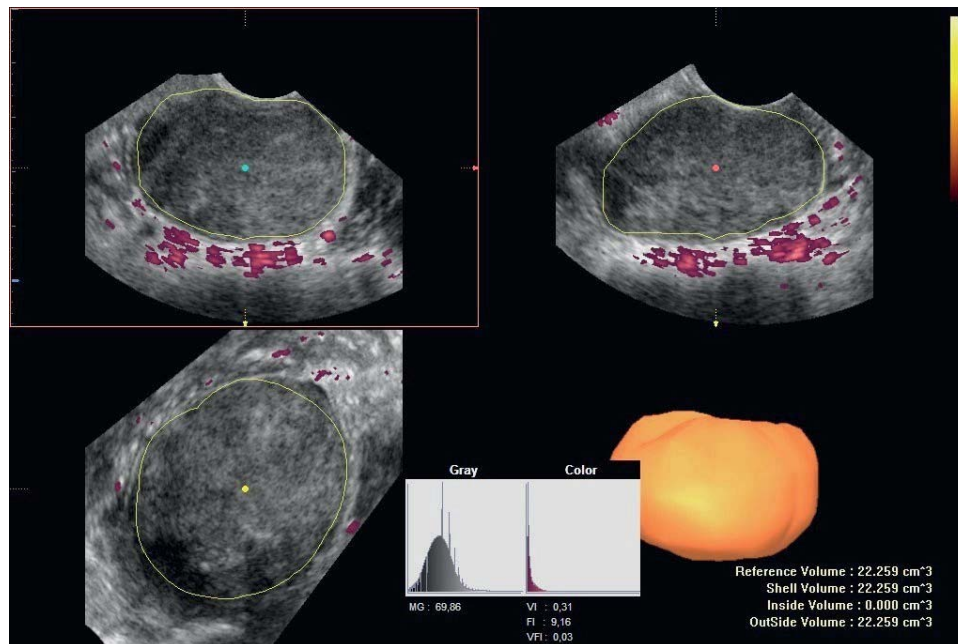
Offline analysis of Power Doppler indices, automatically calculated using the histogram function.
